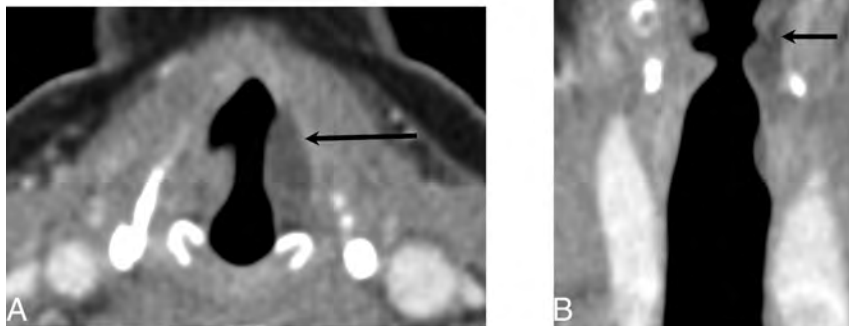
Hyaluronic acid gel. Axial (A) and coronal (B) contrast-enhanced CT at the level of the vocal folds demonstrates fluid attenuation material within the left vocal fold (black arrow).
